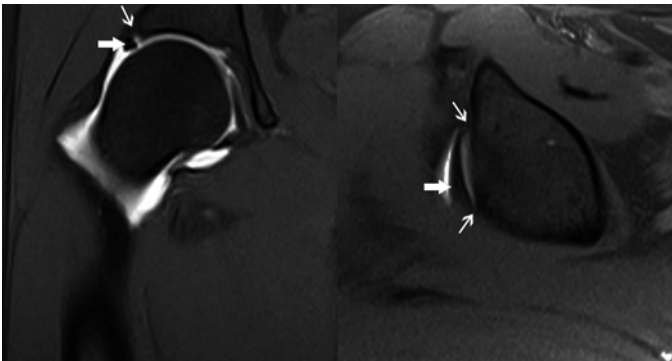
Coronal and axial T1-weighted MR arthrogram of the hip after intracapsular injection of gadolinium-containing contrast agent. A hyperintense fluid cleft (*white arrows*) is seen separating the labrum (*large white arrows*) from the chondral surface of the acetabulum. Findings represent superior labral tear in this patient with cam-type deformity and femoroacetabular impingement.
